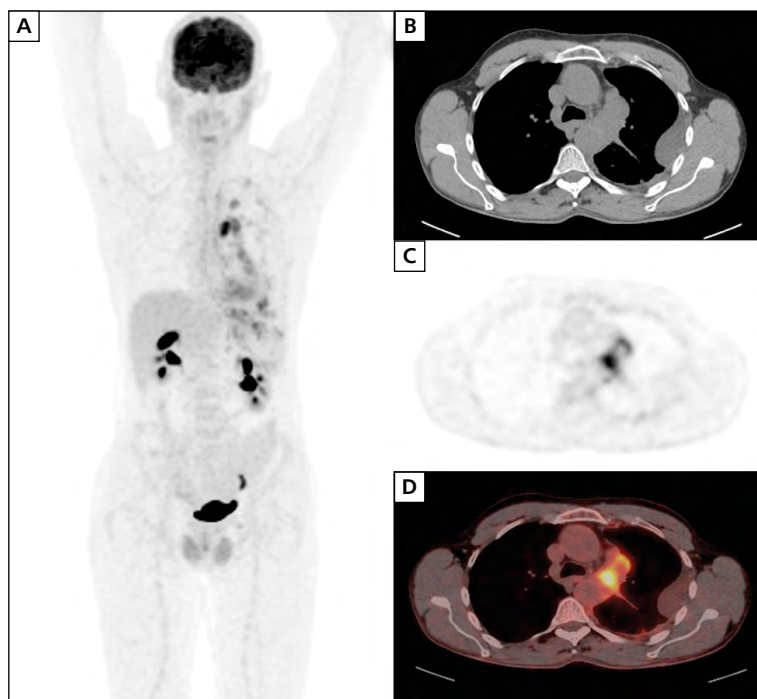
Post-treatment imaging; A. Maximum intensity projection (MIP); B. Computed tomography; C. Positron emission tomography; D. Fusion images
